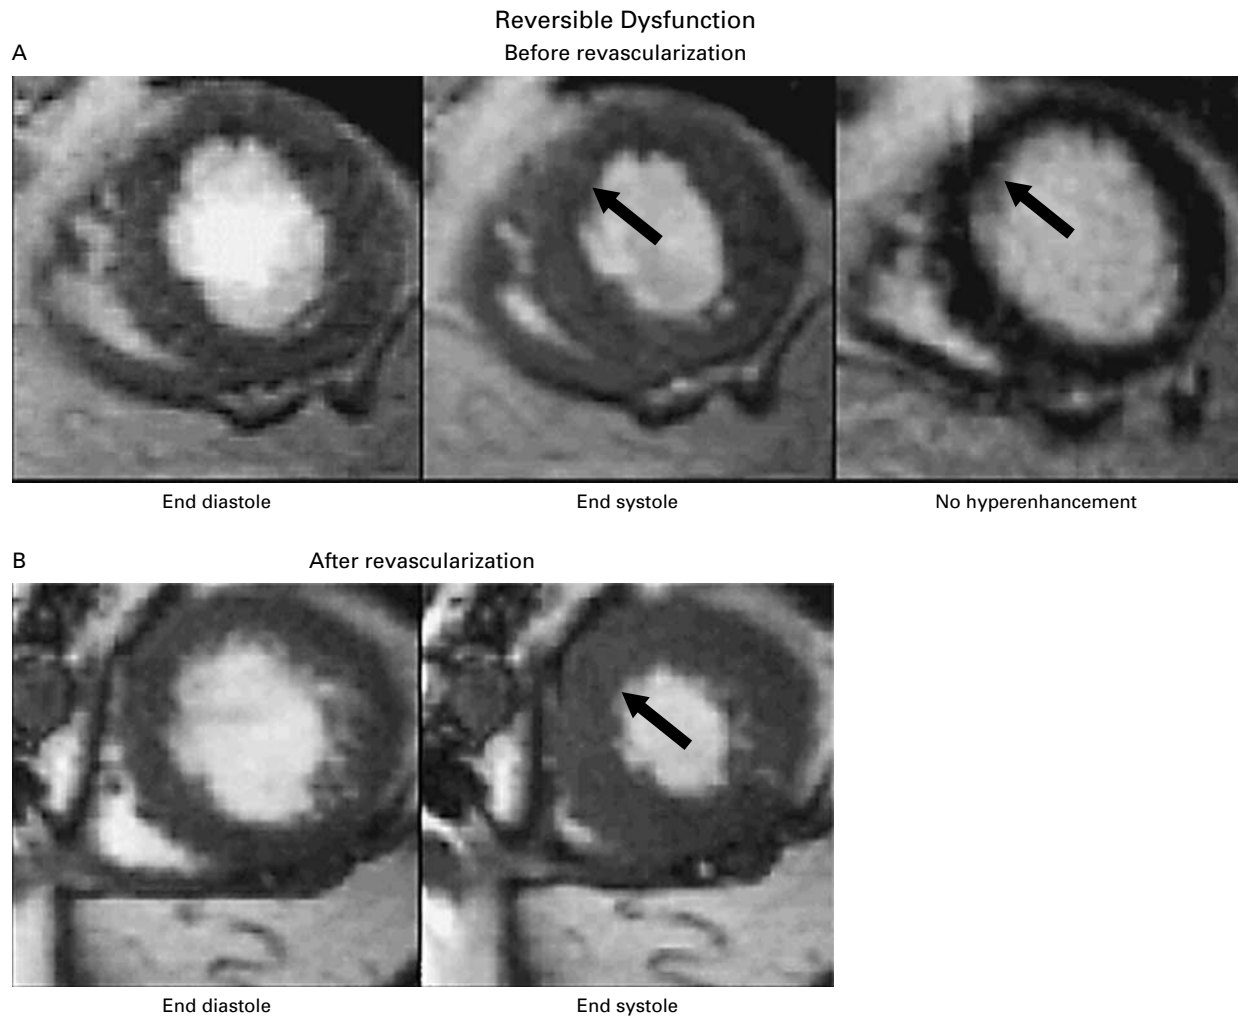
Representative Cine Images and Contrast-Enhanced Images Obtained by MRI in One Patient with Reversible Ventricular Dysfunction (Panels A and B) and One with Irreversible Ventricular Dysfunction (Panels C and D).
